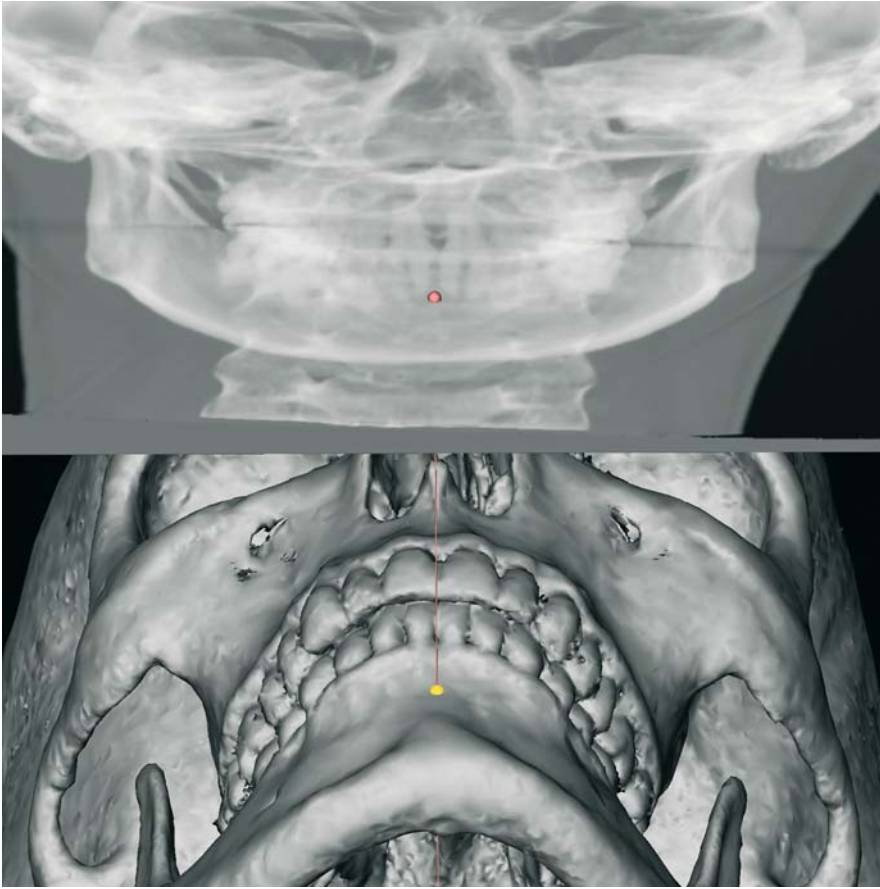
B-Point. Virtual frontal cephalogram linked to the 3-D hard tissue surface representation (3-D CT, patient K.C.)
